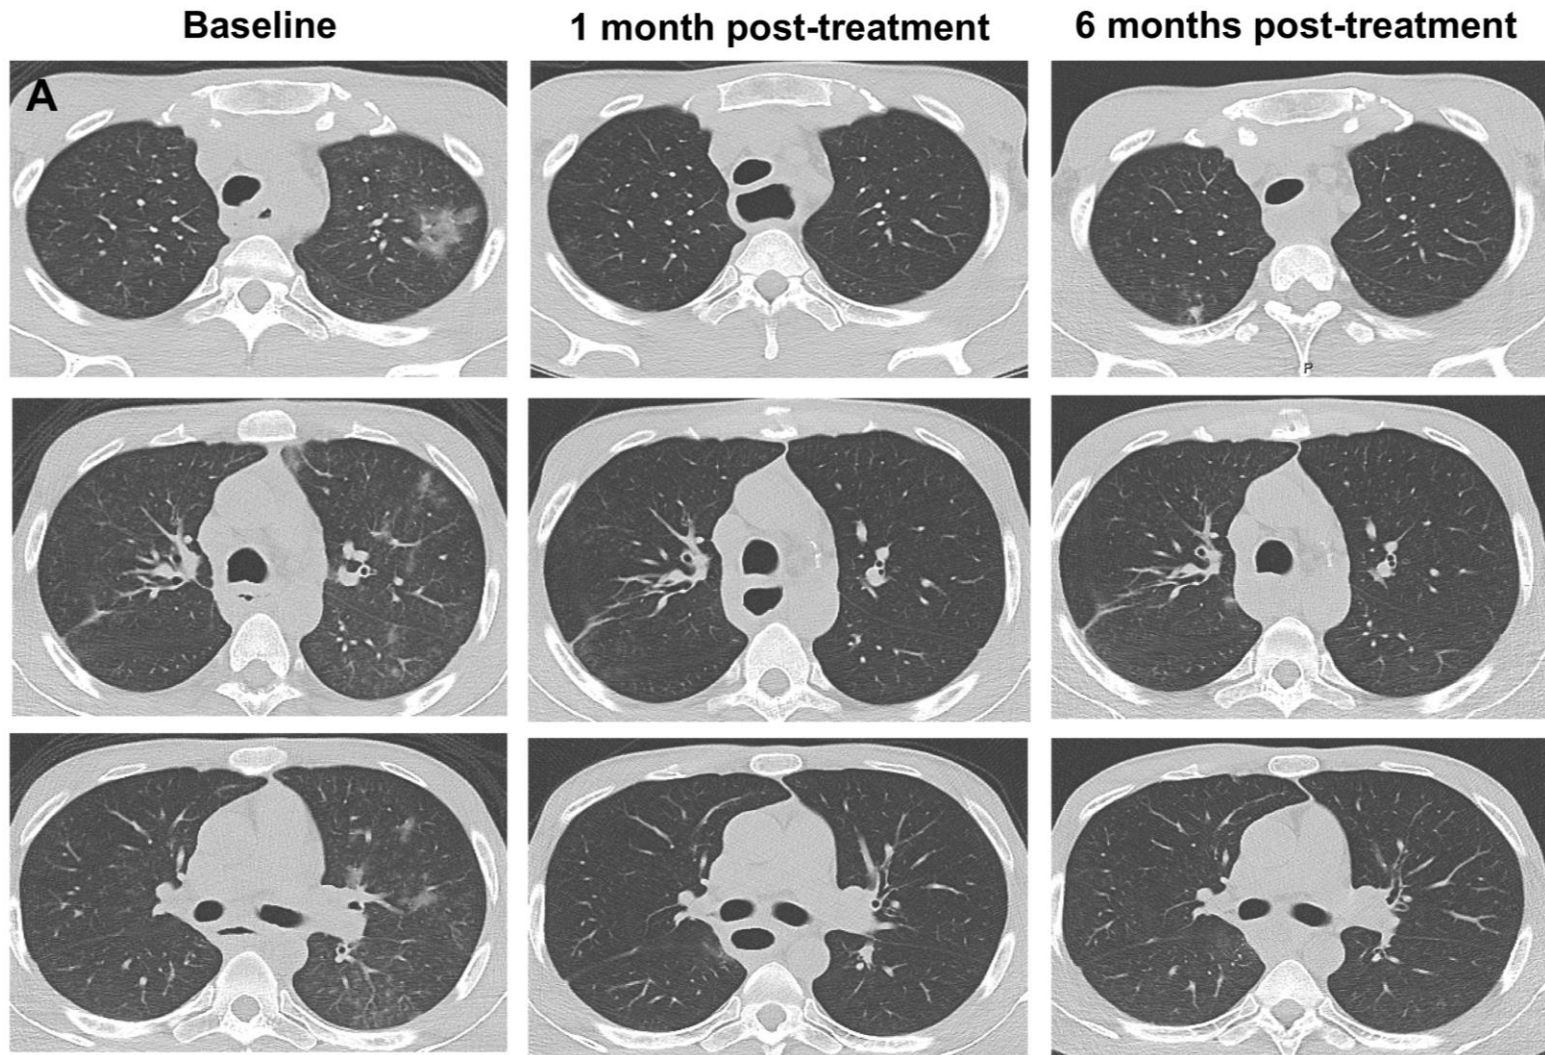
Treatment response assessed by radiography in patient 4. Shown are serial axial (A) and coronal (B) chest CT images and coronal 3D reconstructed CT images (C) at baseline and at 1 and 6 months after treatment initiation.
